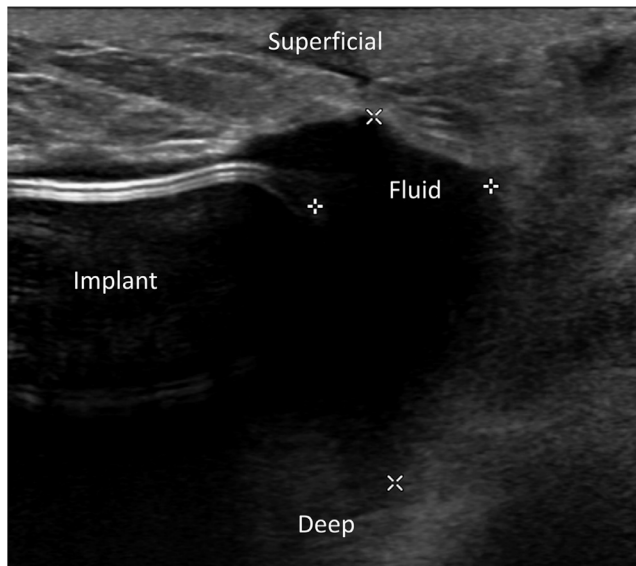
Ultrasound image demonstrating a small collection of homogenous fluid at the superior and lateral pole of the breast outside of her implant at the 11 o'clock position.
